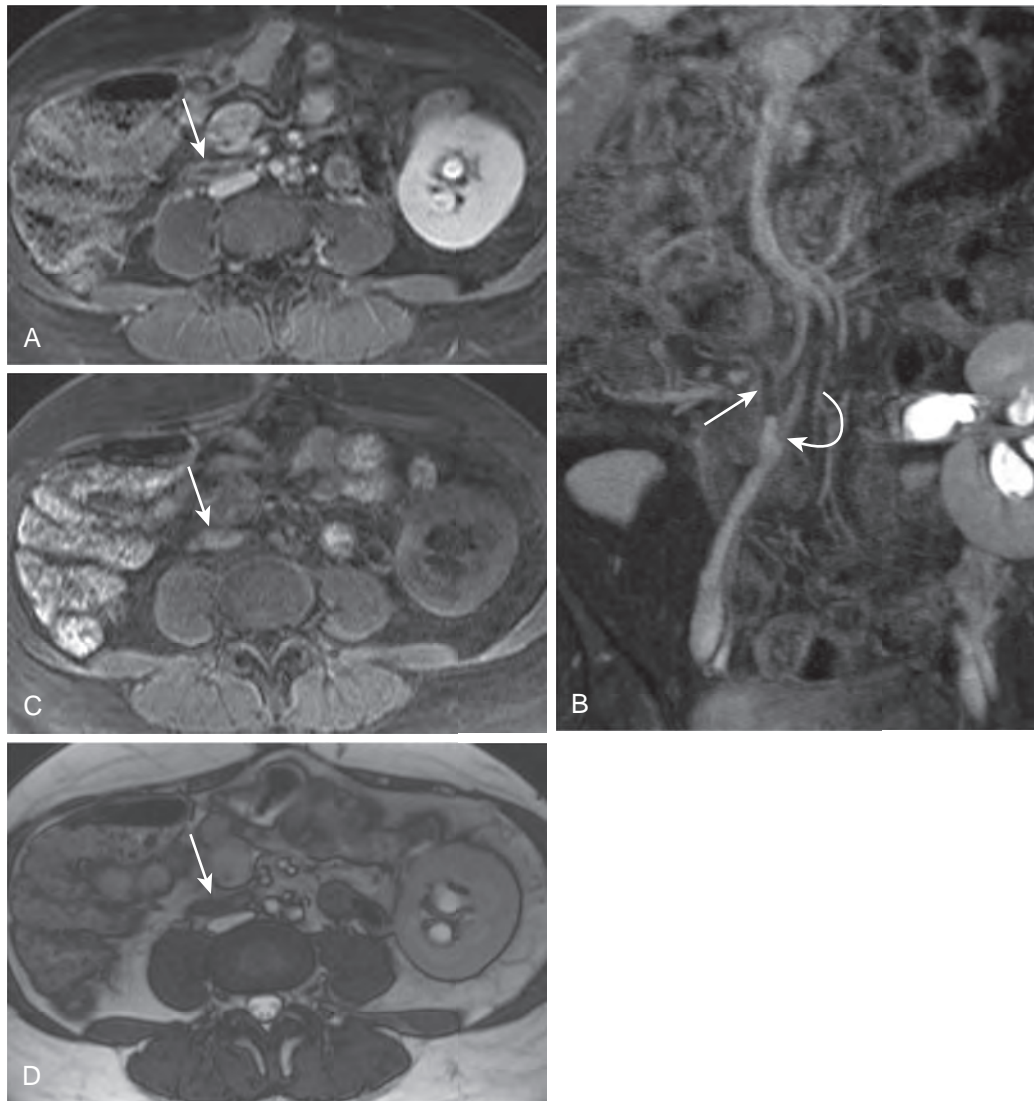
Chronic arterial graft thrombosis in a 45-year-old woman after two failed pancreas transplants. A. Axial gadolinium-enhanced fat-suppressed T1-weighted MR image demonstrates no intraluminal opacification in the graft artery (arrow). B. Coronal oblique maximum intensity projection image derived from data acquired 3 minutes after the initial injection shows loss of intraluminal signal within the graft artery (arrow) just distal to the anastomosis with the right common iliac artery (curved arrow). Note the normally enhancing left lower quadrant renal transplant. C. Axial fat-suppressed T1-weighted image demonstrates high signal thrombus (arrow) in the graft artery. D. Axial TrueFISP MR image shows absence of normal high signal in the graft artery compatible with occlusion (arrow). (From Vandermeer F, Manning MA, Frazier A, et al: *Imaging of whole-organ pancreas transplants*. *RadioGraphics* 32:411–435, 2012.)
